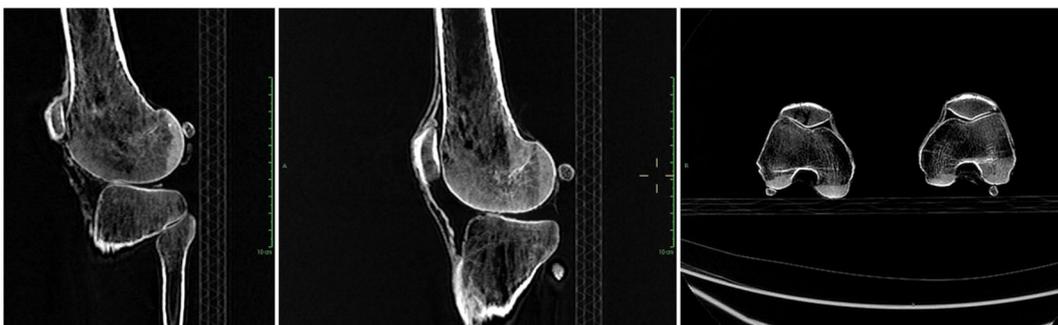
Computed tomography (CT) multiplanar reconstructions of the knees (from left to right: Coronal section of right and left knee; transverse sections of right and left distal femoral epiphyses)
